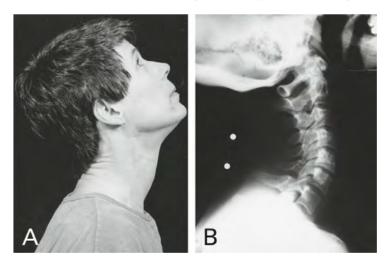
Subject with normal flexibility was photographed and x-rayed in five neck positions. Markers were placed at the hairline and at C7. The photograph shows cervical spine extension by tilting the head in a posterior direction. Note the approximation of the markers on the x-ray.
